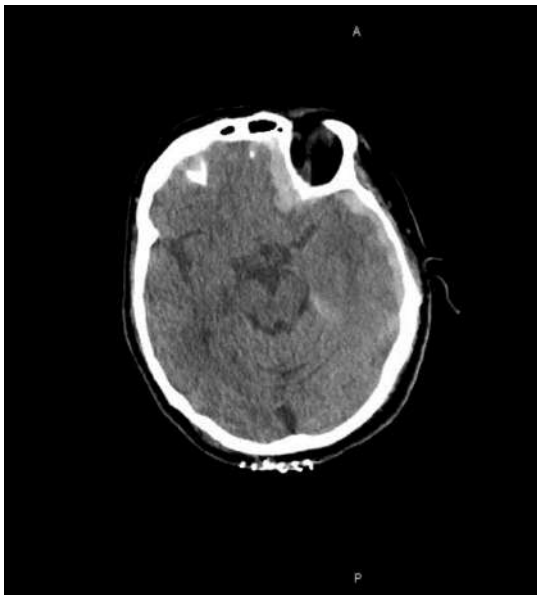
Cranial non - contrast CT
